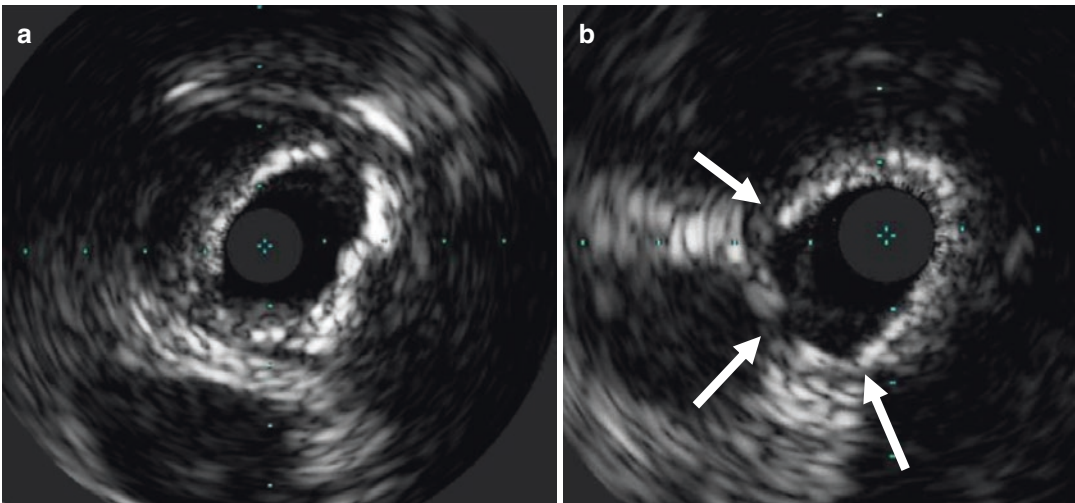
Iterative IVUS imaging for calcified plaque at left anterior descending artery of stable angina patient. (a) Pre-intervention intravascular ultrasound showed superficial calcified plaque with 250° of arc. (b) Post-intervention
